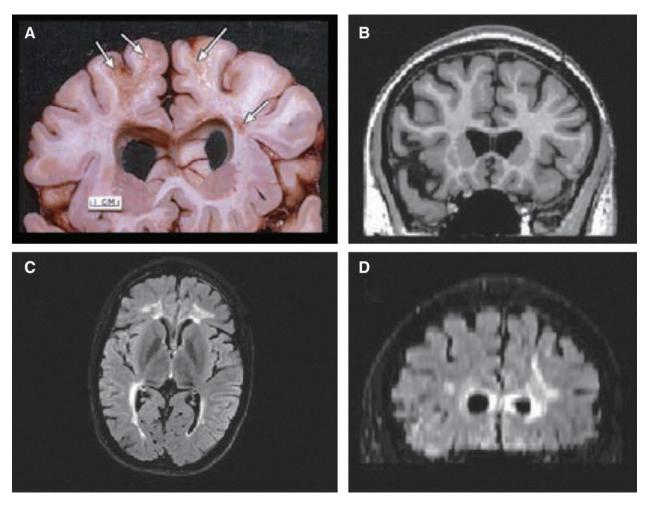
(A) Postmortem from a patient who survived 7 years after severe TBI. Note the dilated ventricles, focal areas of white matter (WM) degeneration (arrows), atrophic corpus callosum, and prominence of the interhemispheric and Sylvian fissures reflective of generalized cortical atrophy. (B) Similar-level T1 MRI coronal section depicting comparable ventricular dilation, and also note the prominence of the cortical sulci and Sylvian fissure as well. (C) Axial fluid-attenuated inversion recovery (FLAIR) sequence depicting bilateral WM signal abnormality. (D) Resliced from the axial acquisition of the FLAIR sequence, this coronal FLAIR image shows extensive WM changes in the periventricular and deep WM of the frontal lobes, in association with the dilated ventricles. The focal areas of WM degeneration that can be seen in (A) will display as signal abnormality in the WM as shown in (D). Reprinted from Bigler and Maxwell (2011), with kind permission of IOS Press.
